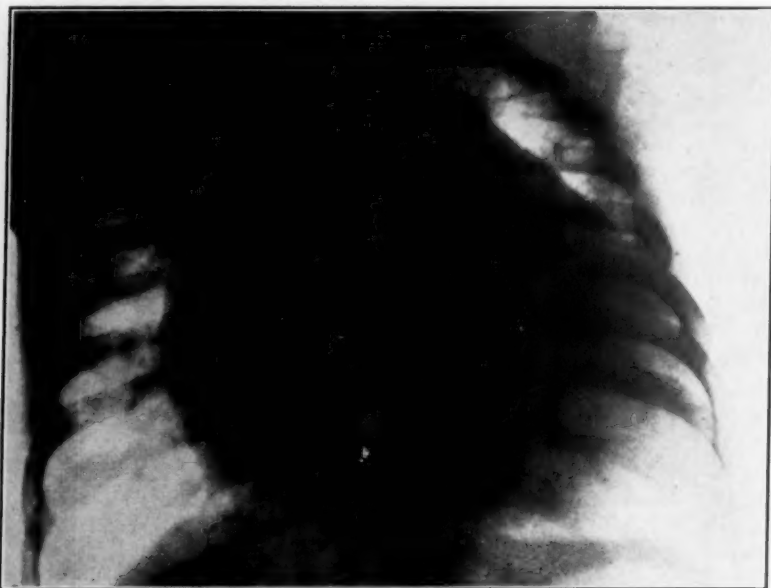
Case 8. Roentgenogram of chest showing marked enlargement of heart with dilatation of left ventricle and some prominence of right border.
